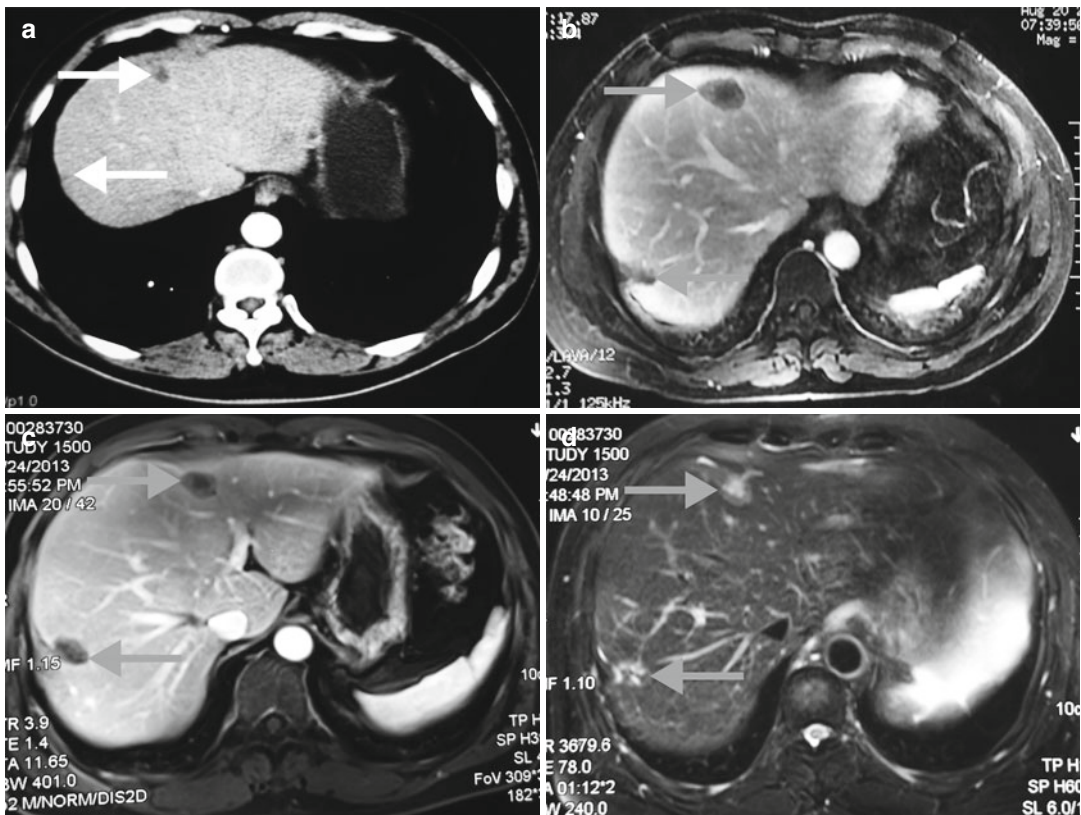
A 47-year-old man with liver metastasis from small intestinal stromal tumour treated with MWA. (a) Preablation-enhanced computed tomography (CT) image shows two hepatic lesions (2.0 cm x 1.7 cm, 0.9 cm x
